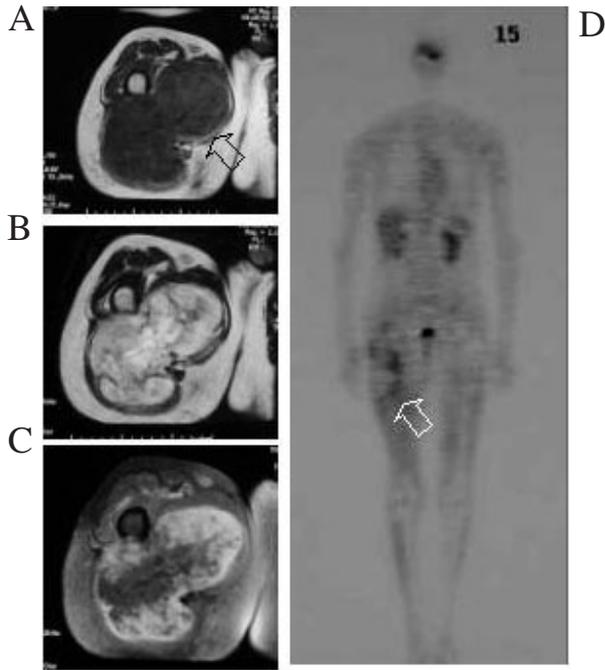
An intramuscular pleomorphic type of liposarcoma that developed in the right thigh in a 66-year-old male (patient number, 54). T1-weighted images (A) show a heterogeneous low-signal lesion with fine gadolinium enhancement (C). T2-weighted images reveal a heterogeneously high signal lesion (B). Whole body scan of FDG-PET reveals heterogeneously increased uptake spots with SUV of 2.4 localized at the margin of the lesion.
